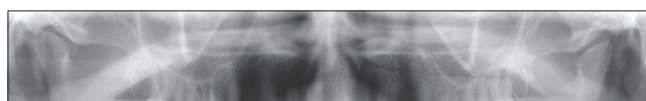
An orthopantomogram which shows symmetry on right and left condyles as bird beak (type III) - bird beak (type III)
